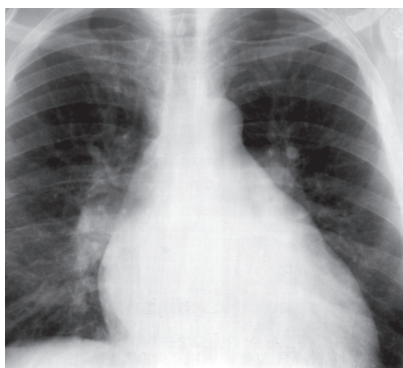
Frontal X-ray. Mitral heart configuration
